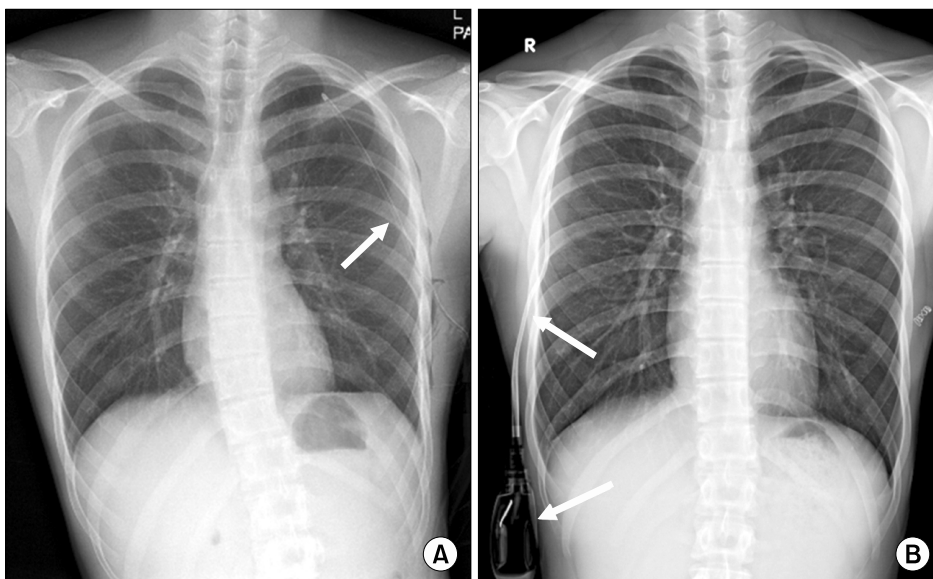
Chest X-ray with (A) 12 Fr chest tube insertion (arrow) and (B) Thoracic Egg (arrows).
